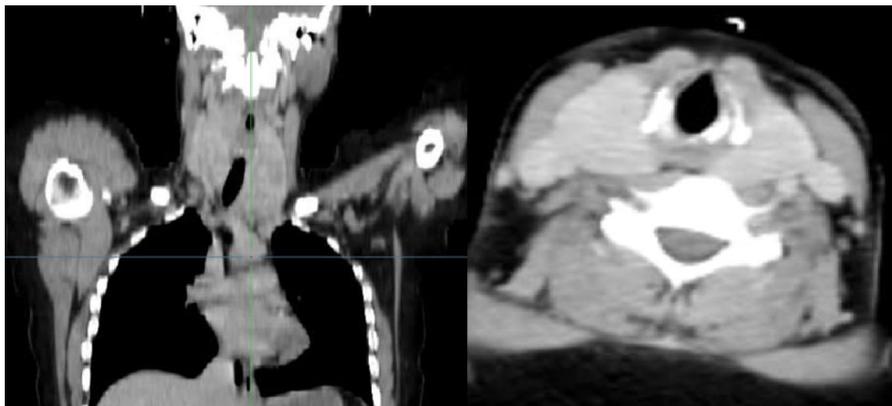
Cervico-thoracic CT scan (coronal and axial views) demonstrating an enlarged thyroid gland with substernal extension causing tracheal deviation and compression
